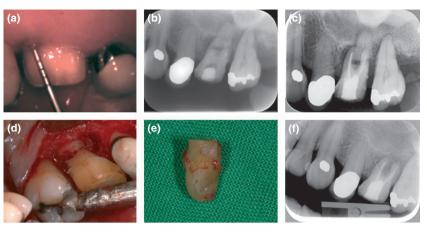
(a) A deep periodontal pocket over the palatal root of tooth 26 was noted. (b) Radiographic examination demonstrated a horizontal radiolucent line on the palatal root and the presence of radiolucent lesions surrounding the palatal and mesiobuccal roots. (c) Radiograph taken after root canal treatment of the mesiobuccal and distobuccal canals. (d) After reflection of a full-thickness flap, displacement of fractured palatal root and an intrabony defect were observed. (e) The extracted palatal root fragment. (f) Radiograph taken 2 months after palatal root amputation showing healing of the bony lesion.
